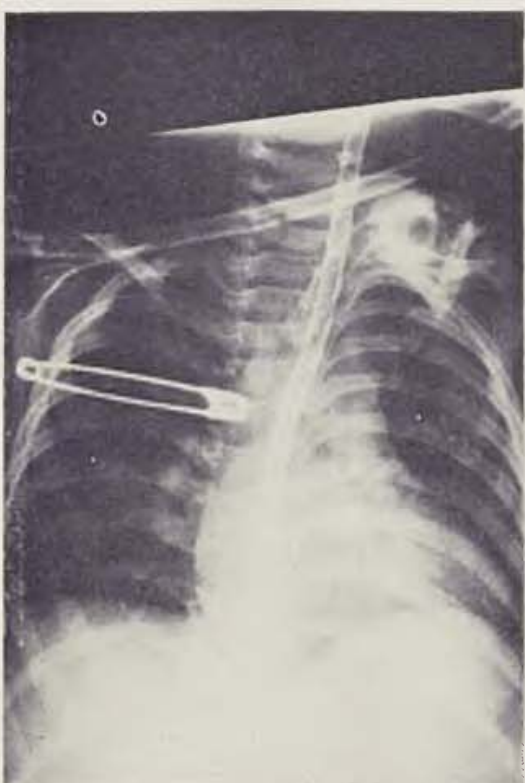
X-ray of the heart and lungs — post-injury day 53. — Fig. 8. X-ray of the heart and lungs — post-injury day 57 (signs of progression)
